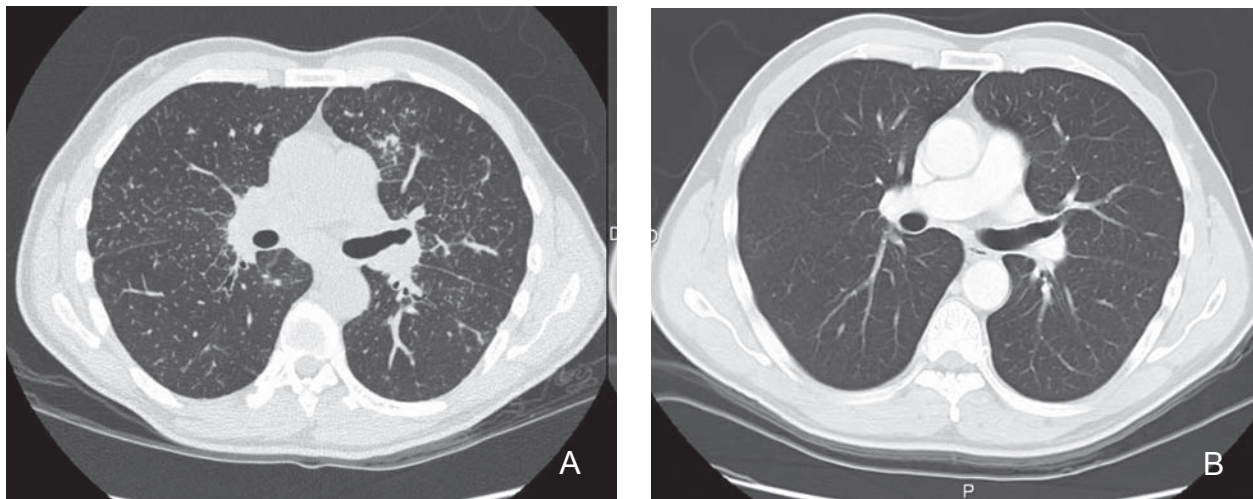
Computed tomographic scan results showed diffuse interstitial-nodular infiltrates (A). Diffuse infiltrates disappeared a year after discontinuation of interferon treatment (B).
